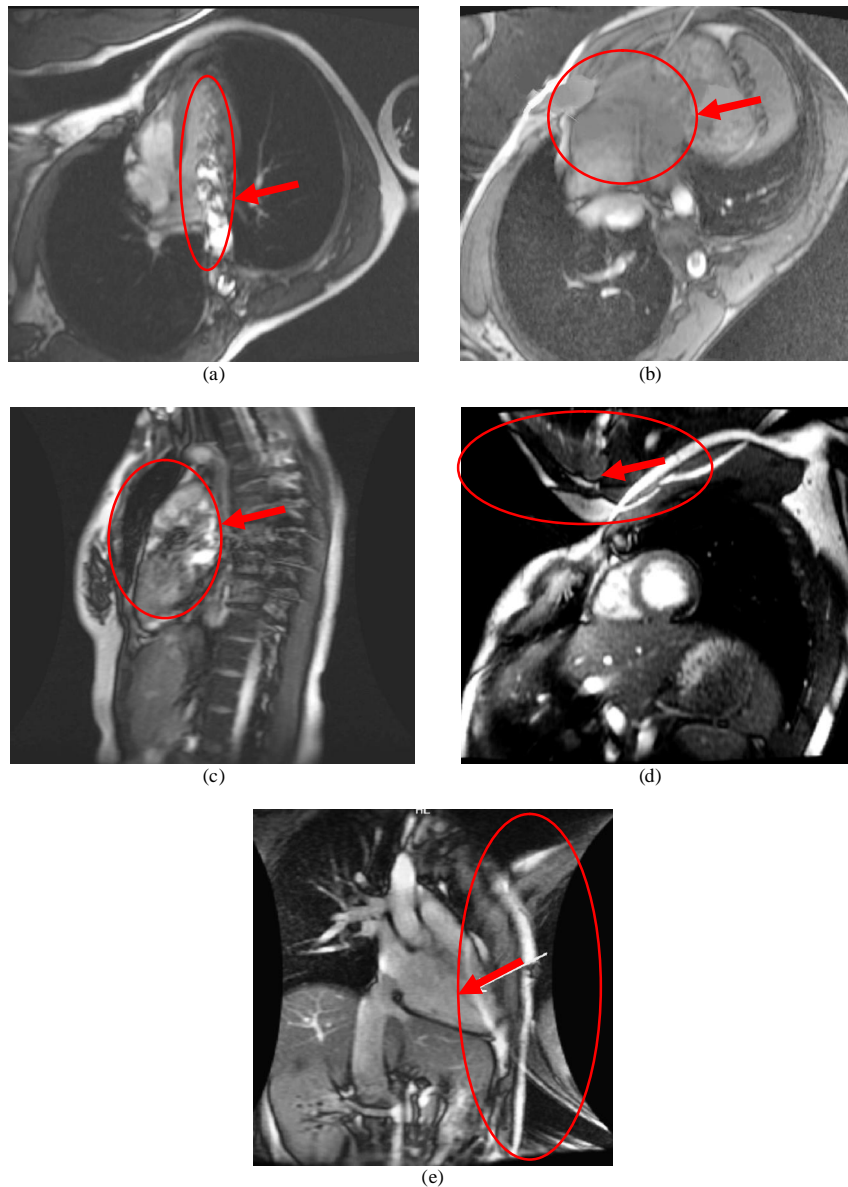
Examples of MRI degraded by image noise [1]. (a) Flow artefact affecting the detection of ventricle edge. (b) Partial volume effect causing uncertainty in determining the amount of blood that is from the left or right ventricle. (c) Patient movement - poor image quality and blood intensity not consistent. (d) Wrap around artefact in SAV. (e) Wrap around artefact in 2CV affecting ventricle edge detection.
